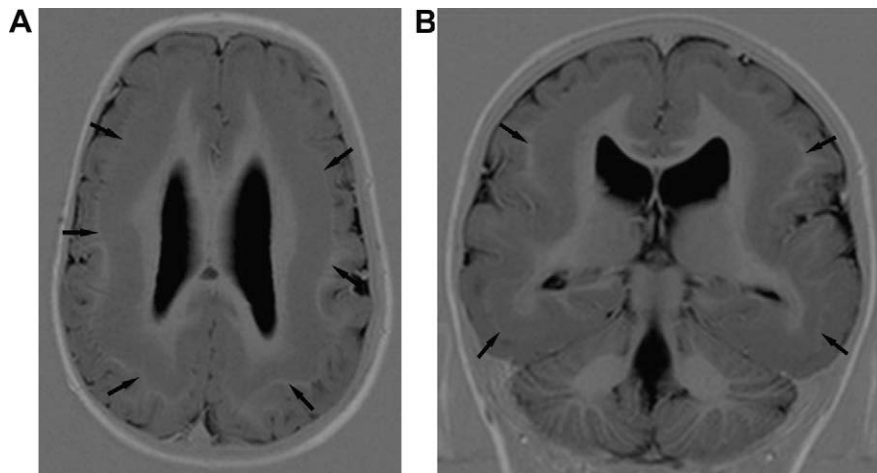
(A and B) FLAIR-MR axial (A) and coronal (B) images, showing homogeneous bands of grey matter between the lateral ventricles and the cerebral cortex, separated from both (see arrows) by a layer of normal-appearing white matter.
